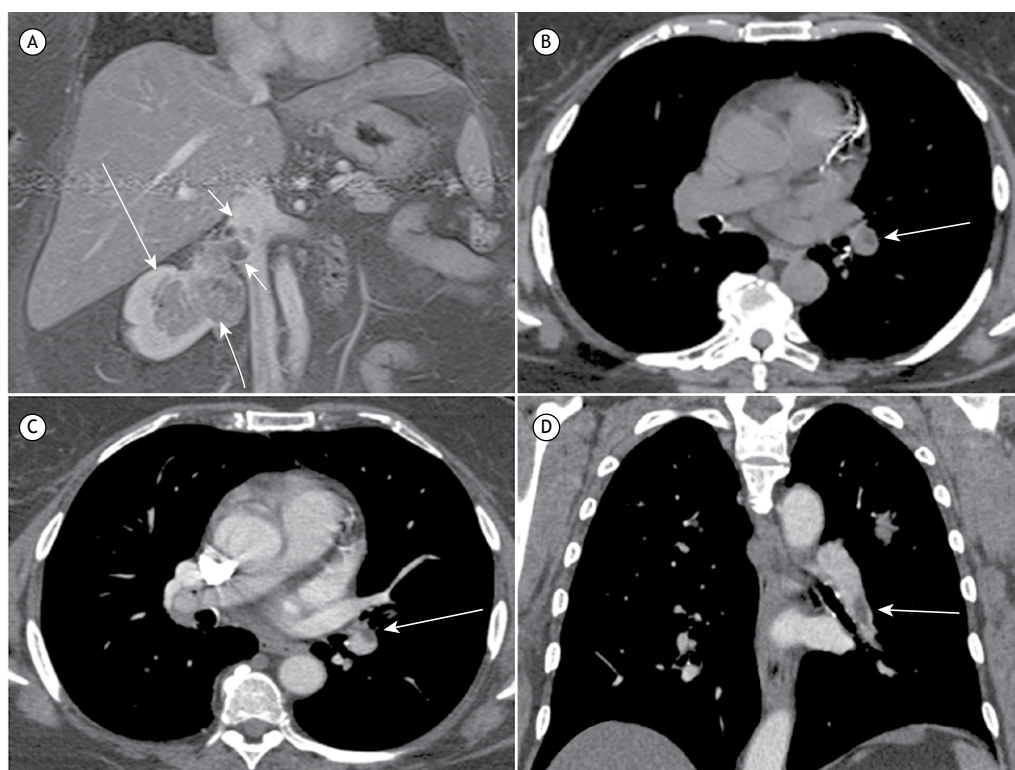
In A, coronal contrast-enhanced fat-saturated T1-weighted magnetic resonance image showing a renal tumor in the renal sinus (arrows), invading the right renal vein and extending into the inferior vena cava (arrowheads). In B, axial CT scan without contrast enhancement, showing a filling defect with fat density in a branch of the left pulmonary artery (arrow). Axial and coronal CT angiography scans of the chest in C and D, respectively, showing a fatty embolus partially obstructing the pulmonary artery branch to the left lower lobe (arrows). Density values for the tumor embolus ranged from –30 to –60 Hounsfield units.
